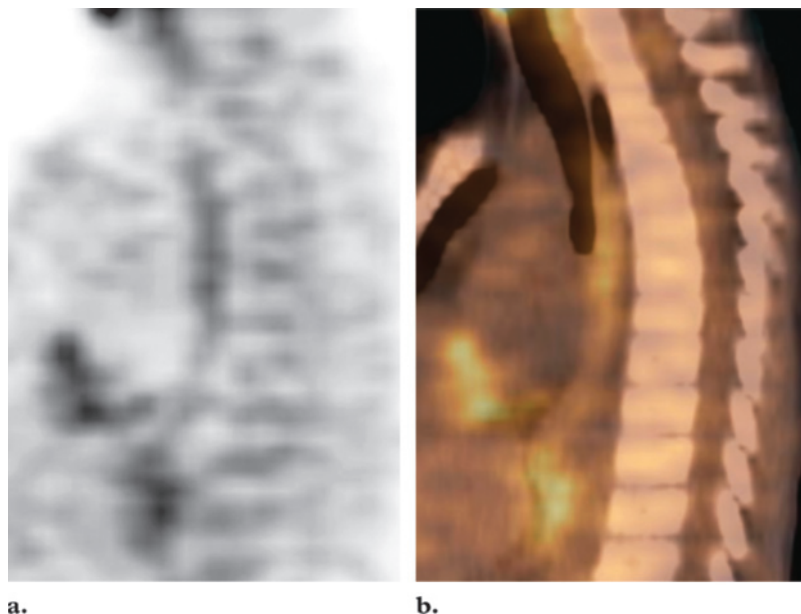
Sagittal FDG PET scan (a) and fused PET/CT image (b) show linear ^{18}F FDG uptake anterior to the thoracic spine (a), a finding that corresponds to the normal esophagus (b).
